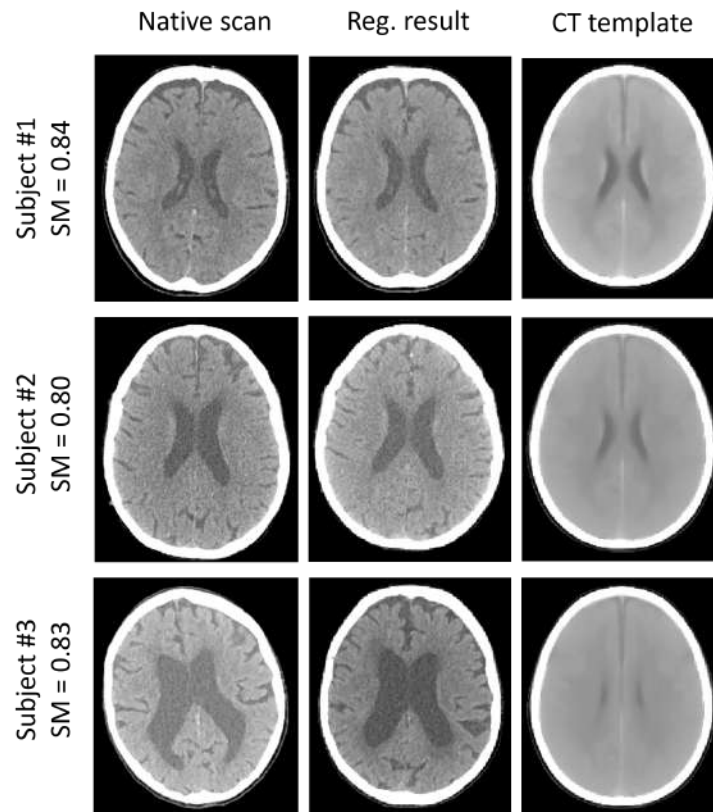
Three qualitative registration results from Dataset 1. Direct affine registration of native CT scans to CT-MNI template.
